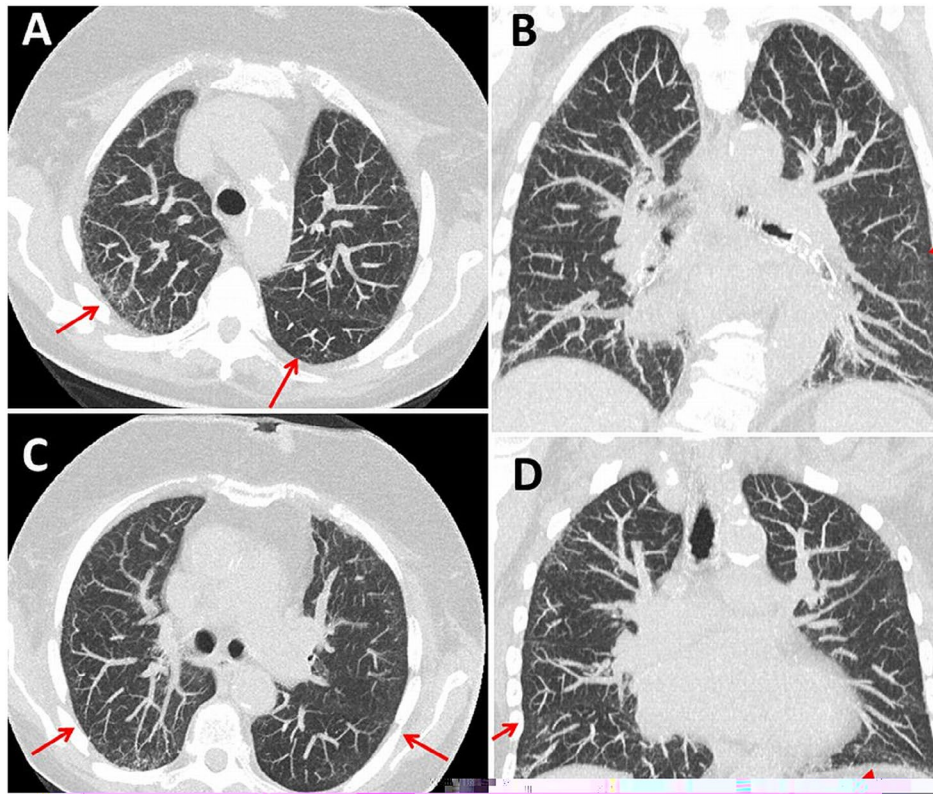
High- resolution chest computed tomography showing reticular densities and ground-glass areas posterolaterally in both upper and lower lobes, being interpreted as early interstitial lung disease (ILD) (panels A–D).
